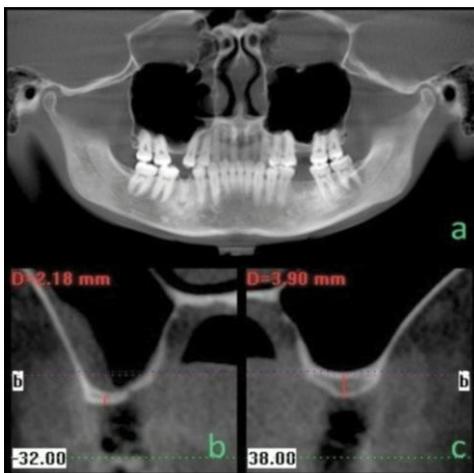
Pre-operative cone beam computerized tomography scan
